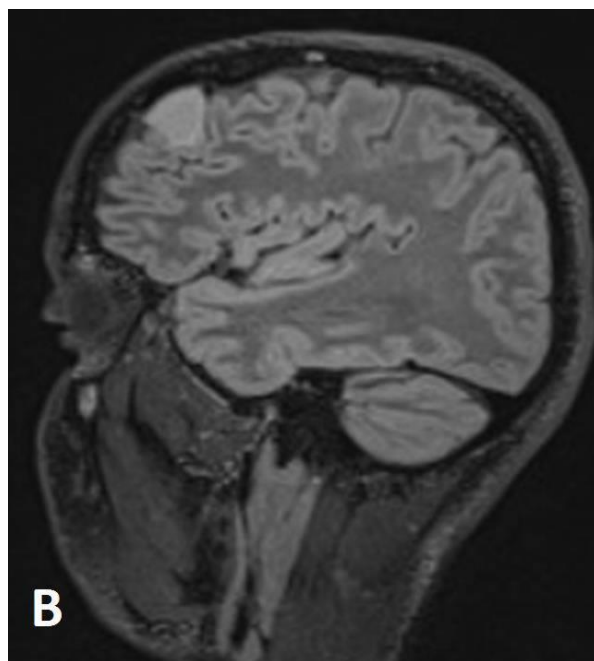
Figure B T2-weighted flair sagittal MRI
